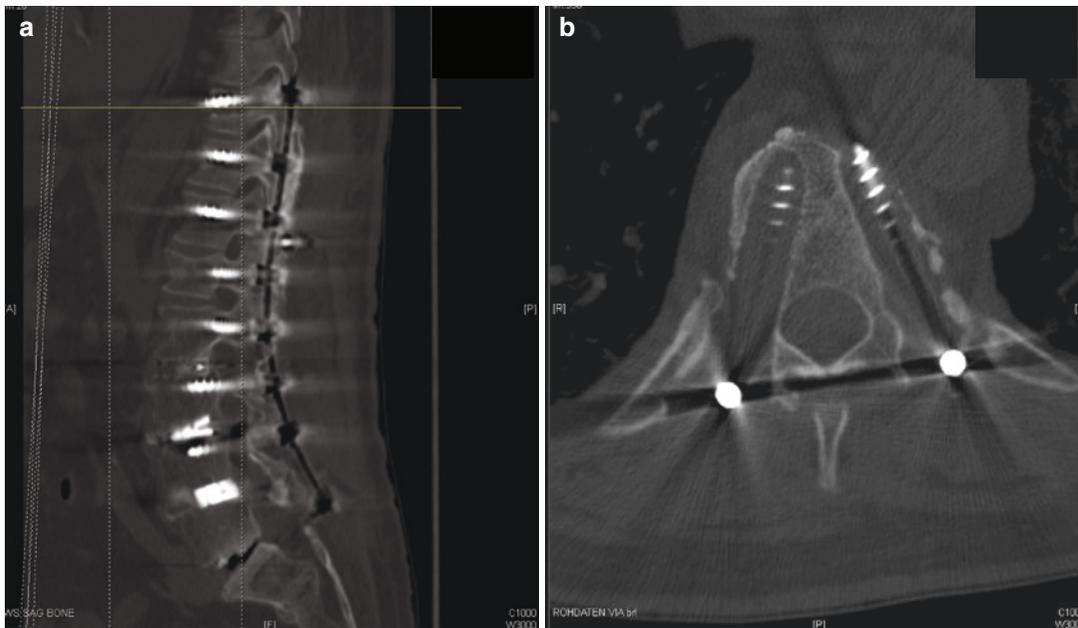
Conventional CT at 1 year post-OP follow-up: (a) sagittal plane demonstrating screw loosening at Th10, 11 and 12 with a consolidated L1 vertebra, (b) axial plane
